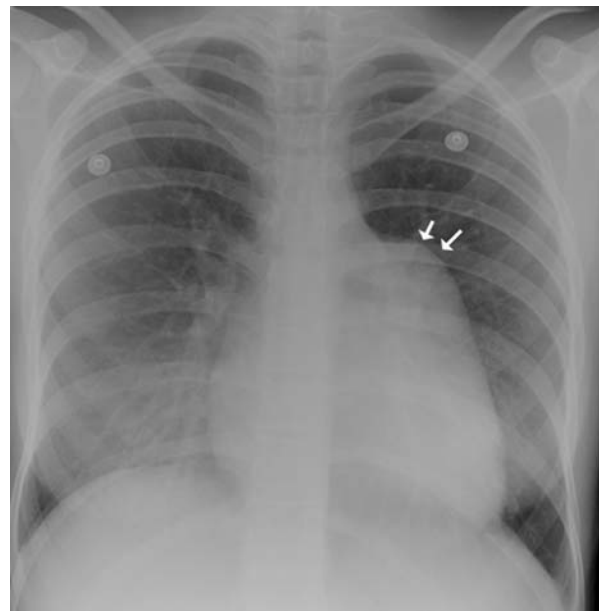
The chest radiograph, as seen in the antero-posterior projection, shows shouldering of the left atrial appendage (white arrows), a characteristic feature of absence of the pericardium.
